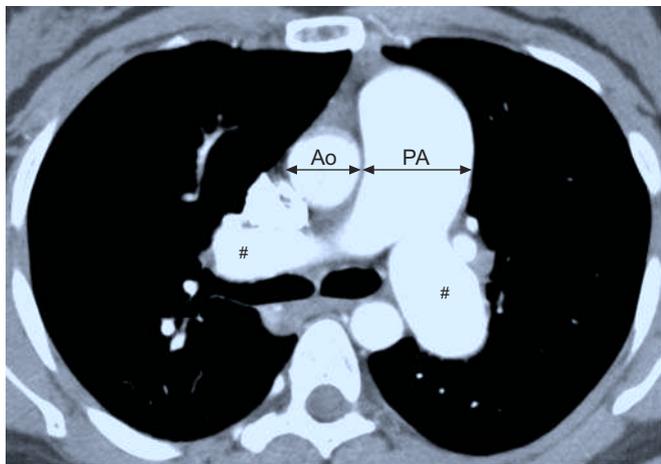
Contrast-enhanced computed tomography of the chest of a patient with pulmonary arterial hypertension associated with congenital heart disease (large atrial septal defect). Massive dilatation of the pulmonary arterial trunk and branches (#). The ratio of the diameter of aorta (Ao) to the diameter of main pulmonary artery (PA) is >1.5 .
